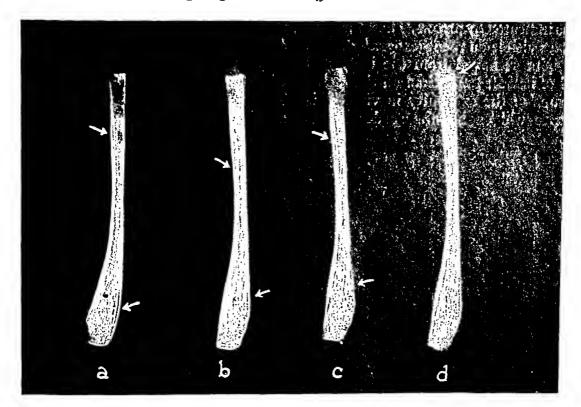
Right ulna (a) turned 15 degrees to the left of the true anteroposterior position: double line visible on lateral aspect of proximal third and medial aspect of middle third of bone; (b) true anteroposterior position: same double lines visible but less pronounced; (c) inclined 15 degrees to the right: double line on proximal third has practically disappeared; line in the middle third is better visible than in (a) and (b); (d) anteroposterior position with the roentgen tube placed distal to the bone and focused on the bone at an angle of 20 degrees: epiphyseal plate projects in form of a curved line (cupping) whereas (a), (b) and (c) show it projected essentially as straight line.
